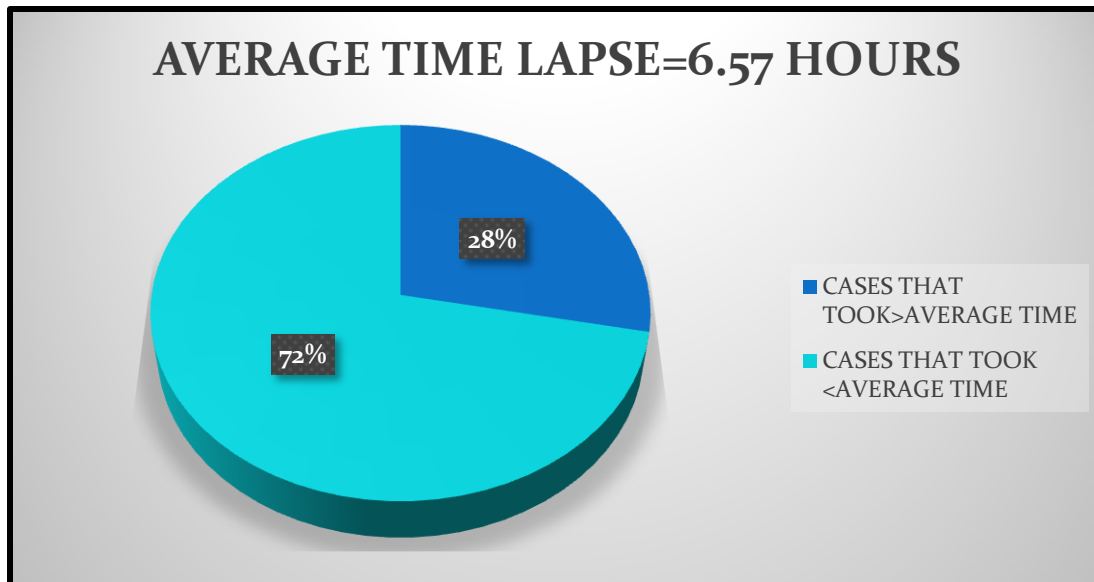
TIME LAPSE BET X-RAY TAKING TIME AND THE TIME AT WHICH REPORTING WAS DONE BY THE RADIOLOGIST.
